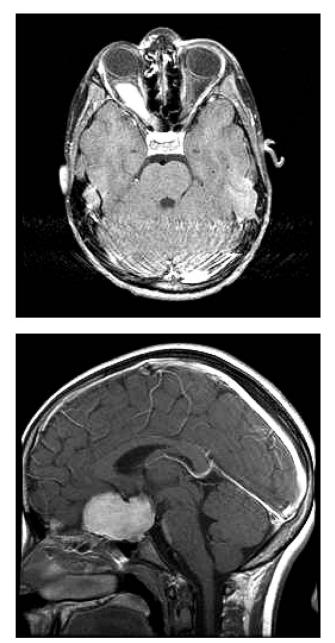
Axial T1-weighted brain MRI after gadolinium administration, demonstrating enhancing right optic nerve glioma. b. Sagittal T1-weighted brain MRI of an enhancing optic nerve/ chiasm glioma that is exophytic into the hypothalamus.
